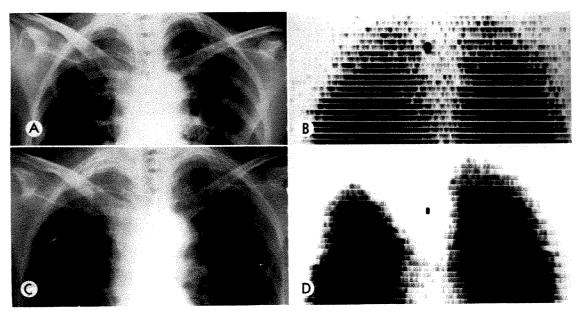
Carcinoma of Breast. (A) Preirradiation chest roentgenogram and (B) lung scan show slight apical pleural thickening and irregular perfusion of the apices respectively. The latter is a common finding. A tumor dose of 4,500 r in 4.5 weeks was then given to the right breast, supraclavicular and internal mammary regions with supervoltage equipment. (C) Six months after completion of treatment, the right apex shows increased pleural thickening and (D) there is markedly impaired perfusion by lung scanning. Patient RK, a 50 year old female.
